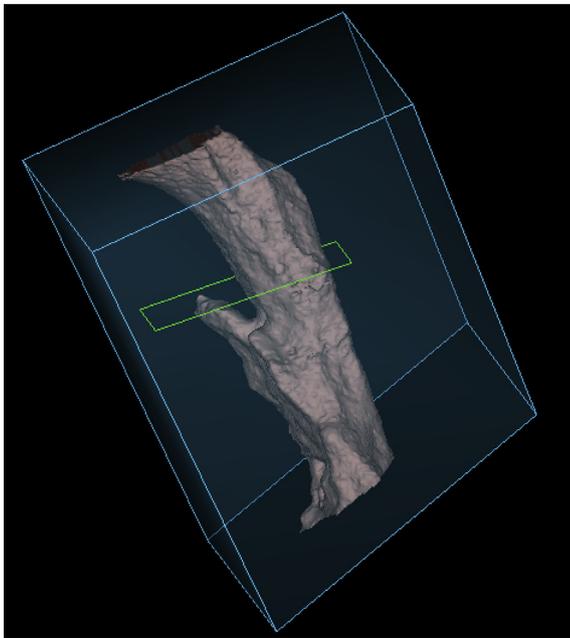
Computed tomography in a sagittal section showing the volume of pharyngeal airway space (PAS) in postoperative period.
